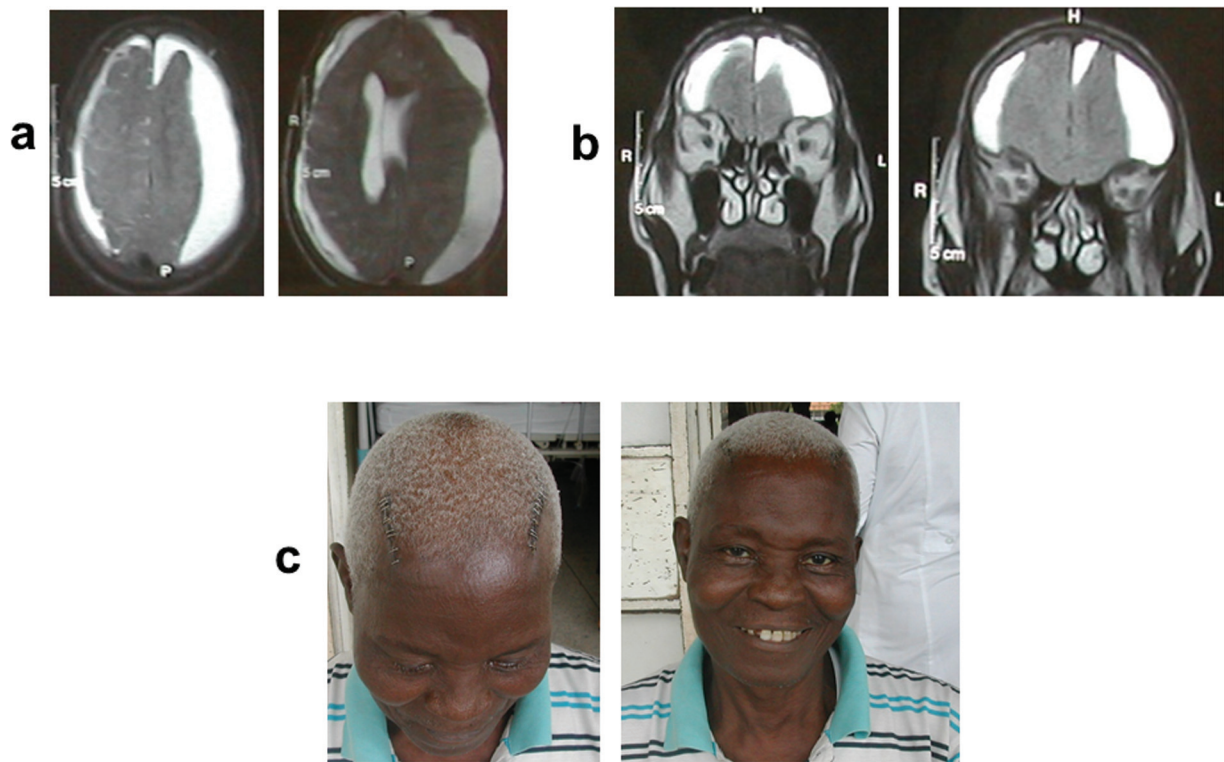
A 78-year-old man was operated with this technique for symptomatic bilateral chronic subdural hematoma. The preoperative MRI cuts are shown in the (a) axial and (b) coronal cross-sections. (c) The patient, on postoperative day 7 when the wound staples were removed.
